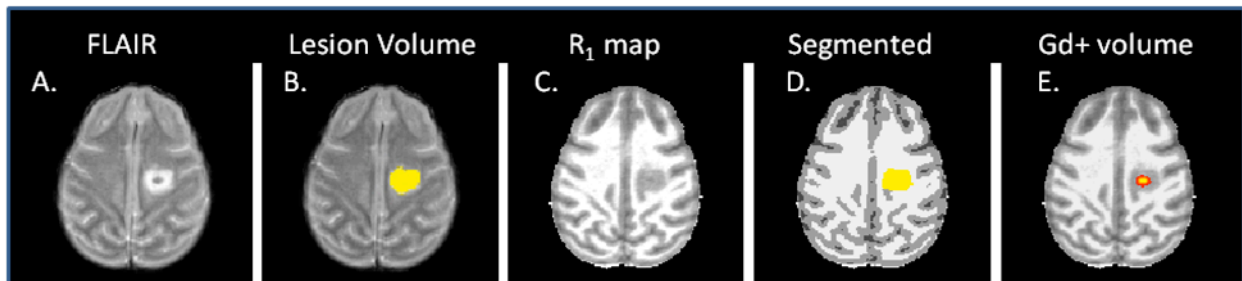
Example of tissue morphometric analysis in JME brain. The FLAIR image is used to identify WM signal hyperintensities which are classified as lesion volume. R_1 maps are generated by solving the Bloch equations as described in text. Tissue segmentation of the R_1 maps into gray matter, white matter and cerebrospinal fluid was carried out using histogram inspection along with an automated segmentation tool [2]. These segmented images were manually edited to reclassify hypointense lesions within the white matter that had been misclassified as gray matter. Contrast enhanced images were created by subtracting pre-contrast R_1 maps from post-contrast R_1 maps and manually delineating regions of high delta R_1 within brain tissue, excluding major vessels. These regions of contrast enhancement were then overlaid on the pre-contrast R_1 map. For this individual we estimate the tissue properties: 54.6% normal appearing gray matter, 34.9% normal appearing white matter; 10% cerebrospinal fluid, and 0.6% lesion.
